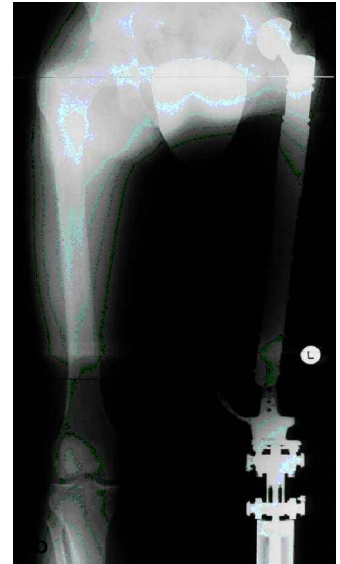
The distal end-piece should be covered with a well-perfused muscle flap (a). The radiographic follow-up (including the exoprosthesis) shows a hip subluxation, which caused no symptoms (b) in case no. 5 (extraarticular resection of a multicentric hemangioendothelioma).
